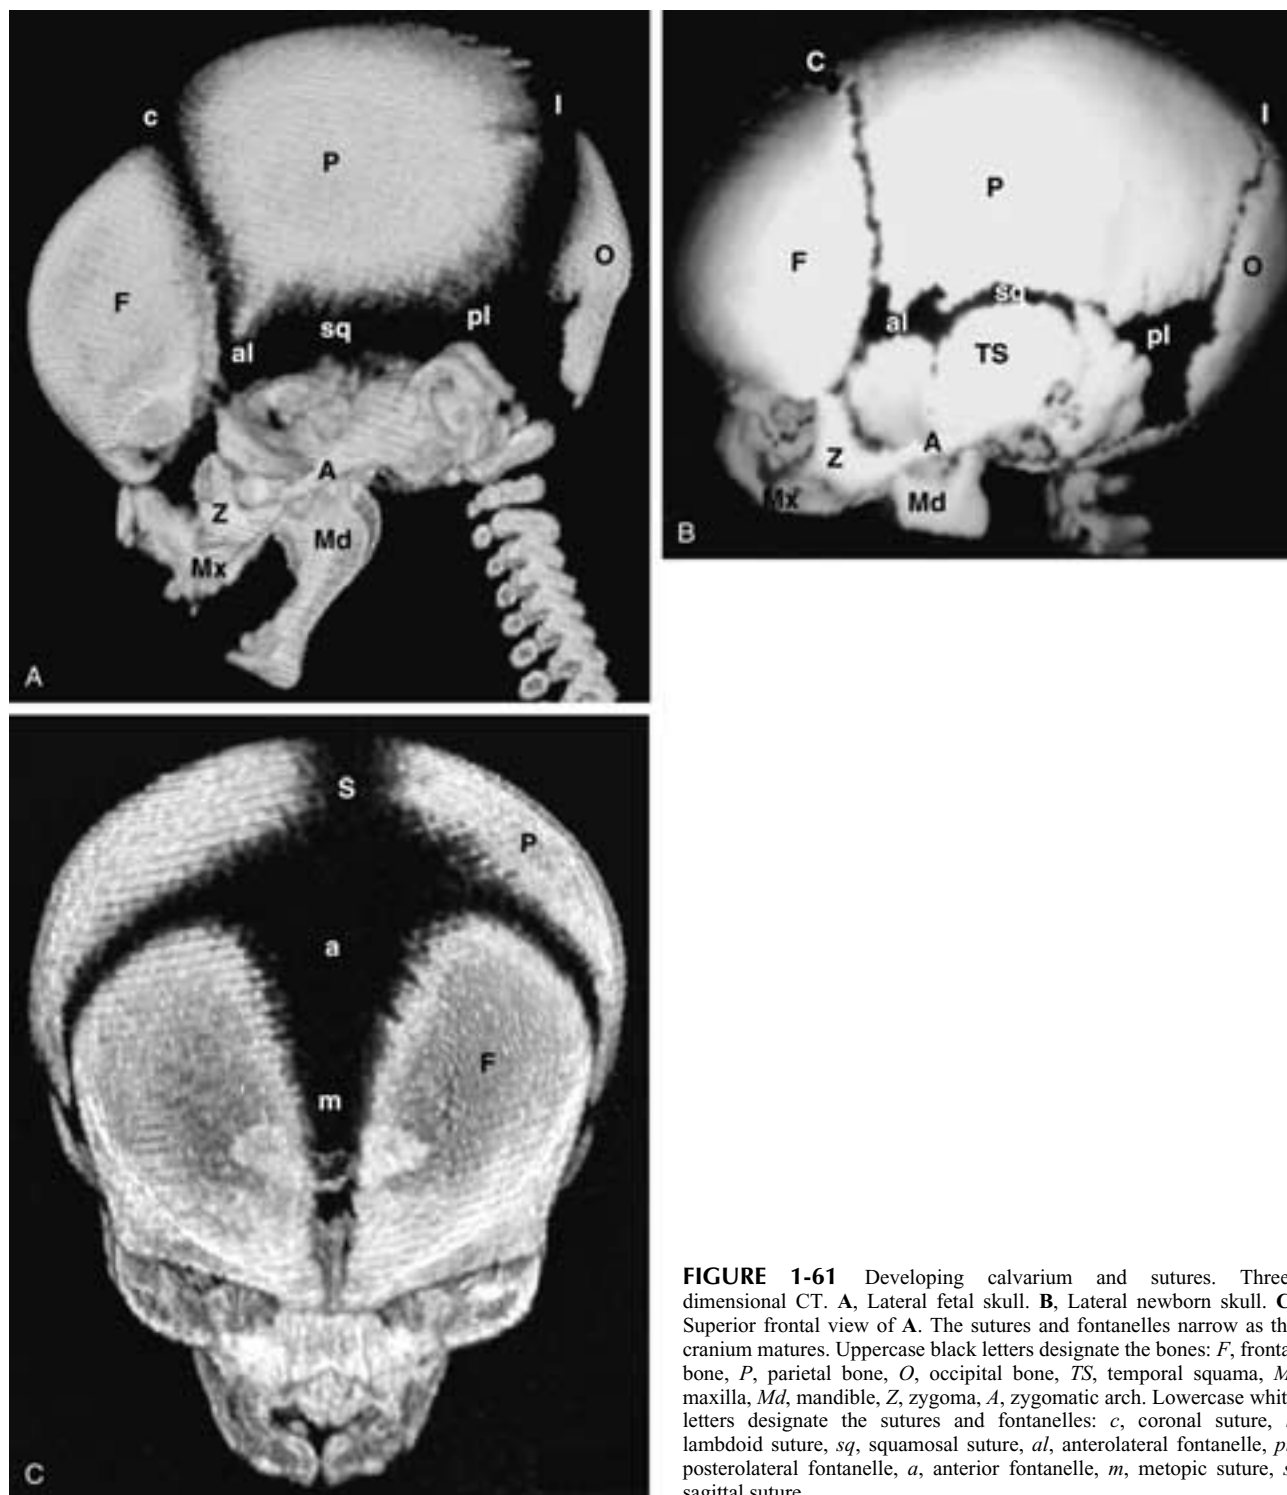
Developing calvarium and sutures. Three-dimensional CT. A, Lateral fetal skull. B, Lateral newborn skull. C, Superior frontal view of A. The sutures and fontanelles narrow as the cranium matures. Uppercase black letters designate the bones: *F*, frontal bone, *P*, parietal bone, *O*, occipital bone, *TS*, temporal squama, *M*, maxilla, *Md*, mandible, *Z*, zygoma, *A*, zygomatic arch. Lowercase white letters designate the sutures and fontanelles: *c*, coronal suture, *l*, lambdoid suture, *sq*, squamosal suture, *al*, anterolateral fontanelle, *pl*, posterolateral fontanelle, *a*, anterior fontanelle, *m*, metopic suture, *s*, sagittal suture.
